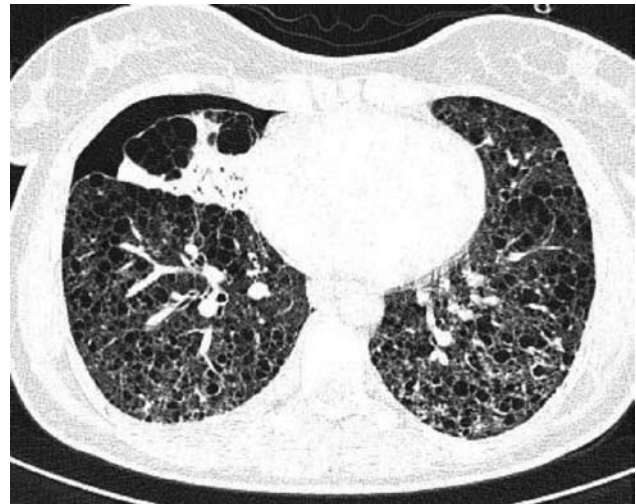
HRCT demonstrated bilateral numerous well-defined thin-walled cysts surrounded by normal parenchyma, traction bronchiectasis, honeycombing, airflow obstruction, air trapping, and formation of bullae and pneumothorax.
